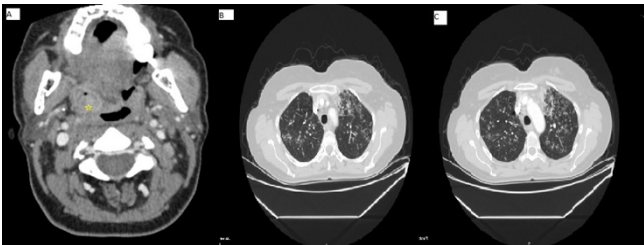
FIGURE A: Mass lesion visible in the oropharynx on neck computed tomography (CT)
